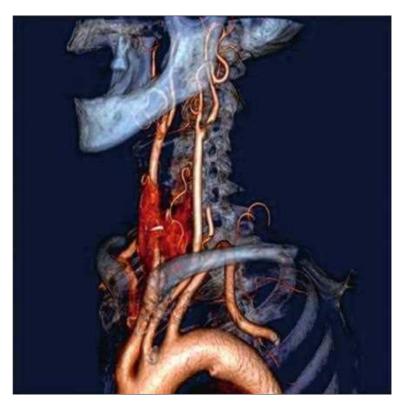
CT Angiogram of the Carotids. Note the simultaneous demonstration of the surrounding bony landmarks.
